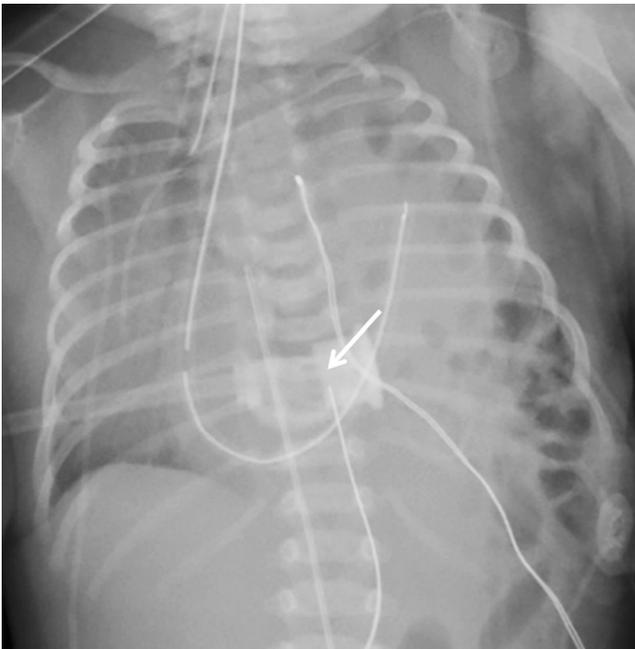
Anteroposterior radiograph of the chest in a newborn girl. The radiology report excerpt was as follows: “The endotracheal tube terminates about 1–2 cm above the carina. Left-sided PICC line terminates in the distal superior vena cava. UA catheter now terminates at T6-T7. UV catheter terminates in the right atrium.” The UVC (umbilical venous catheter) (*arrow*) terminating at the level of T10 was misinterpreted as being in the right atrium rather than in a suboptimal intrahepatic location. *PICC* peripherally inserted central catheter, *UA* umbilical arterial, *UV* umbilical venous
